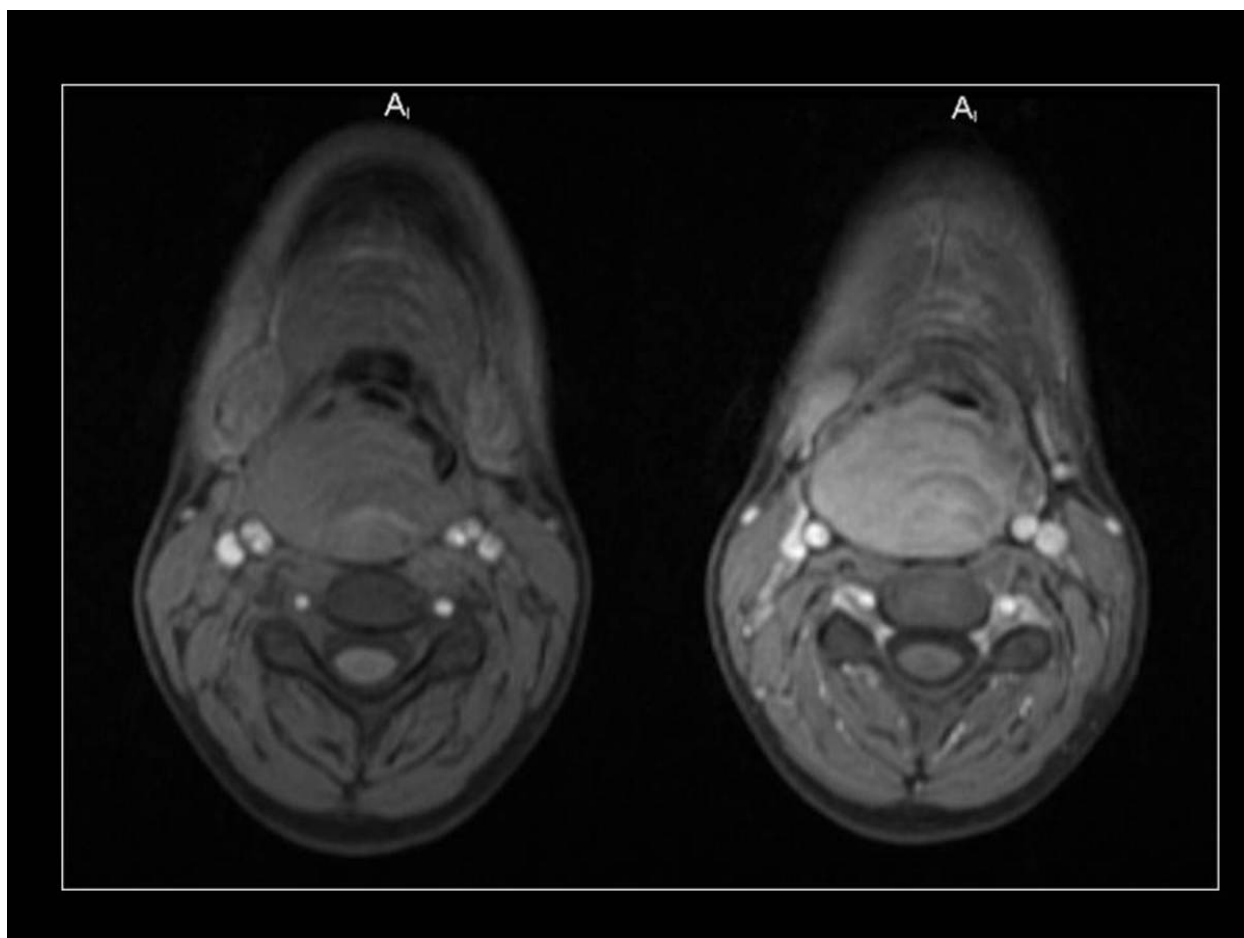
Nodular fasciitis. Same patient as Fig.32. Axial mid-cervical FSE MR images, T1-weighted (left) and T2-weighted (right). An oval-shaped, solid, homogeneous, with high SI on T2WI and intermediate SI on T1WI mass displaced the pre-vertebral muscles posteriorly and the hypopharynx and larynx anteriorly, suggesting a retropharyngeal origin. No clear signs of invasion of these structures were observed. There were no signs of invasion of the prevertebral muscles or cervical spine either. Acknowledgment to the Department of Radiology of the Hospital Pediátrico de Coimbra.
